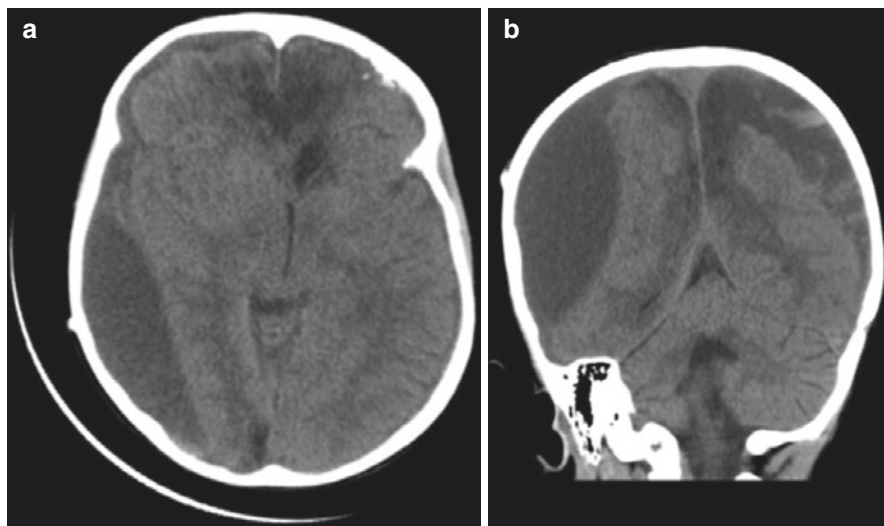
Axial (a), coronal (b) non-enhanced computed tomography (NECT) sections demonstrating bilateral chronic subdural hematoma (CSDH) on post-shunt imaging of a 10-year-old male patient
